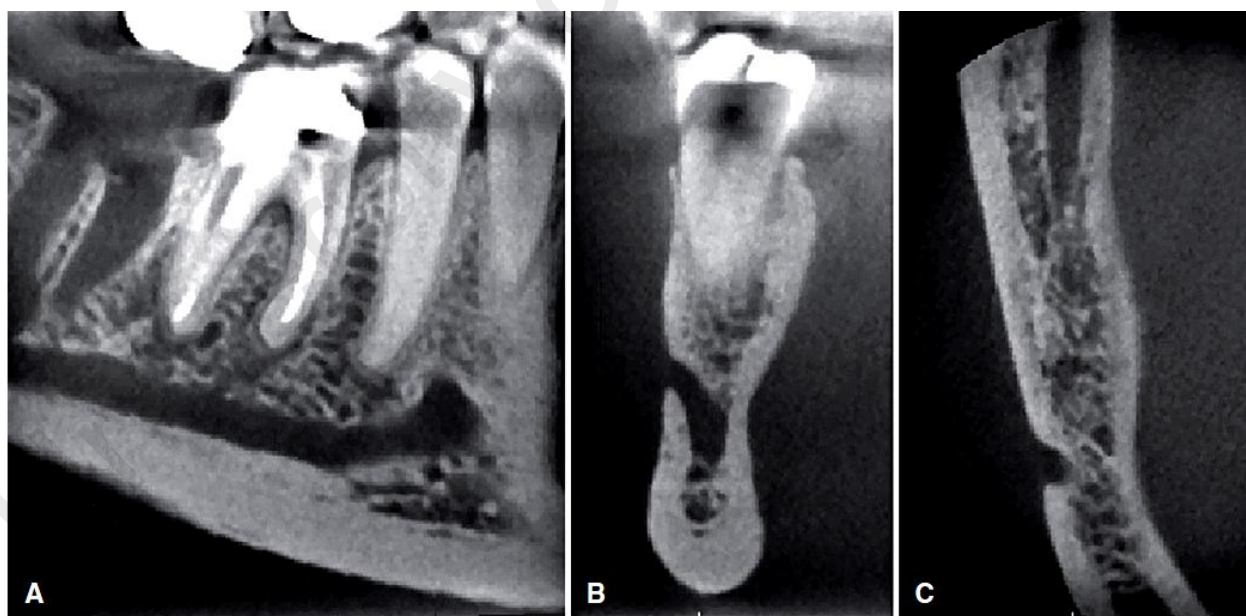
CBCT images showing mental foramen from different views. A, Sagittal section of mandible showing mandibular canal rising toward mental foramen which lies anterior to the apex of 2<sup>nd</sup> premolar. B, coronal section through mental foramen showing mandibular canal ascends to exit through mental foramen (Buccal cortex). C, axial aspect of mandible showing mental foramen opening is posteriorly inclined on buccal cortex. (images enhanced with third part image editing software) (White & Pharoah, 2014).
